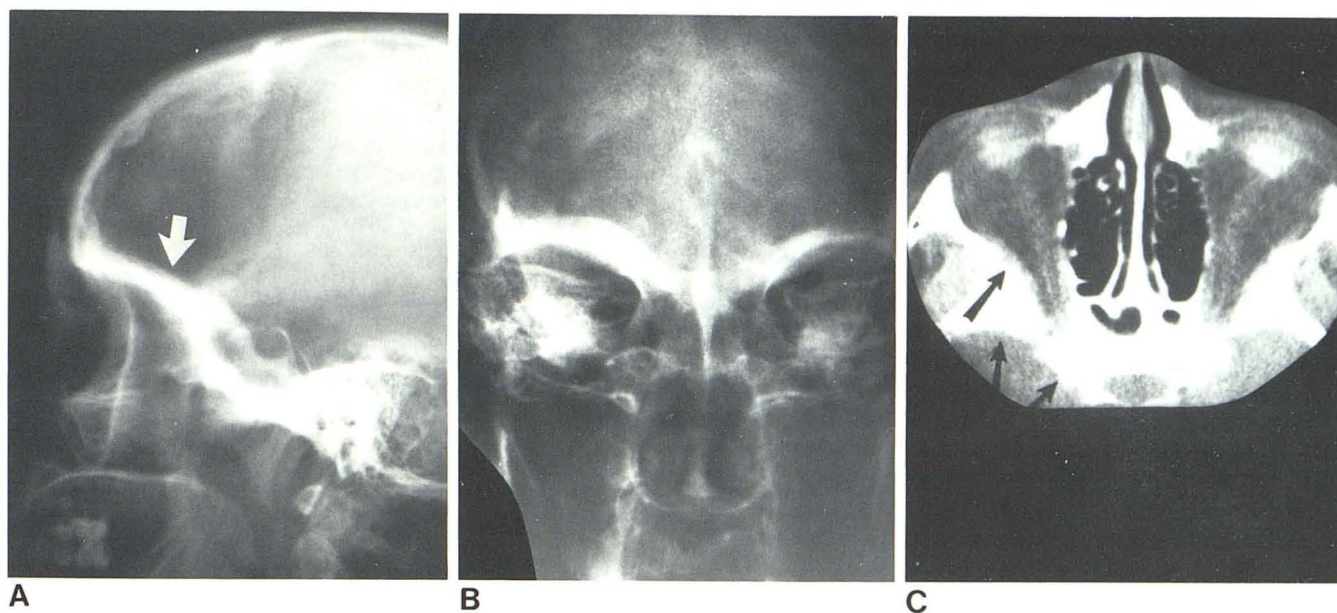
Case 11. Sarcoid in skull. A and B, Sclerosis of right orbital plate of frontal and sphenoid bones. C, CT scan after contrast enhancement. Bone thickening and paraosseous plaque enhancement in right middle cranial
